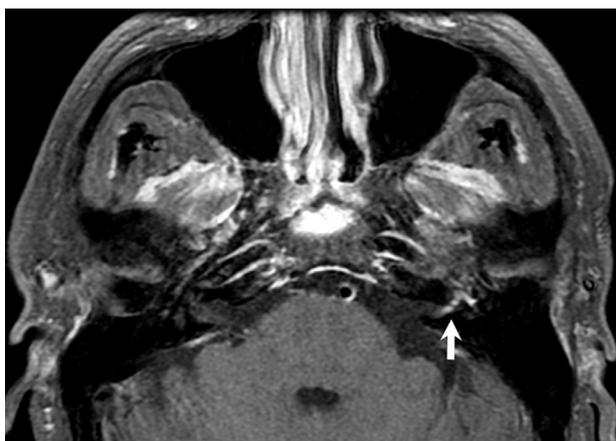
Bell's palsy with facial nerve neuritis in a 60-year-old male with new onset of facial nerve paralysis. Axial T1-weighted postcontrast fat-saturated image demonstrates smooth linear enhancement and enlargement of the distal intracanalicular, labyrinthine and anterior tympanic segments of the left facial nerve (white arrow) characteristic of neuritis. The patient's facial nerve palsy and the abnormal enhancement both resolved as is common in the normal course of Bell's palsy.
